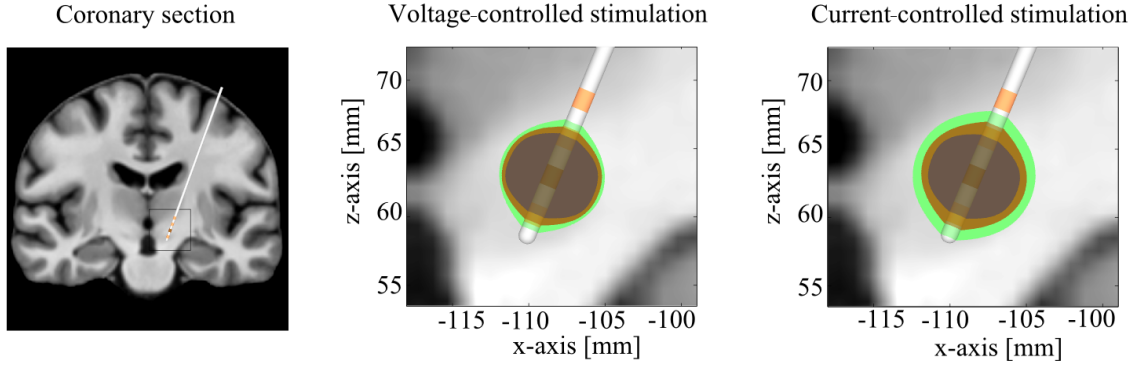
Coronary section of the MRI data set with the DBS electrode overlaid with the probabilistic VTA for voltage-controlled and current-controlled stimulation with $A_{vc} = -1.5$ V and $A_{cc} = -1.5$ mA, respectively. The mean value (orange), 0.025 quantile (dark blue), and 0.975 quantile (green) for a probabilistic conductivity with $\sigma_r = 20$ % are shown.
